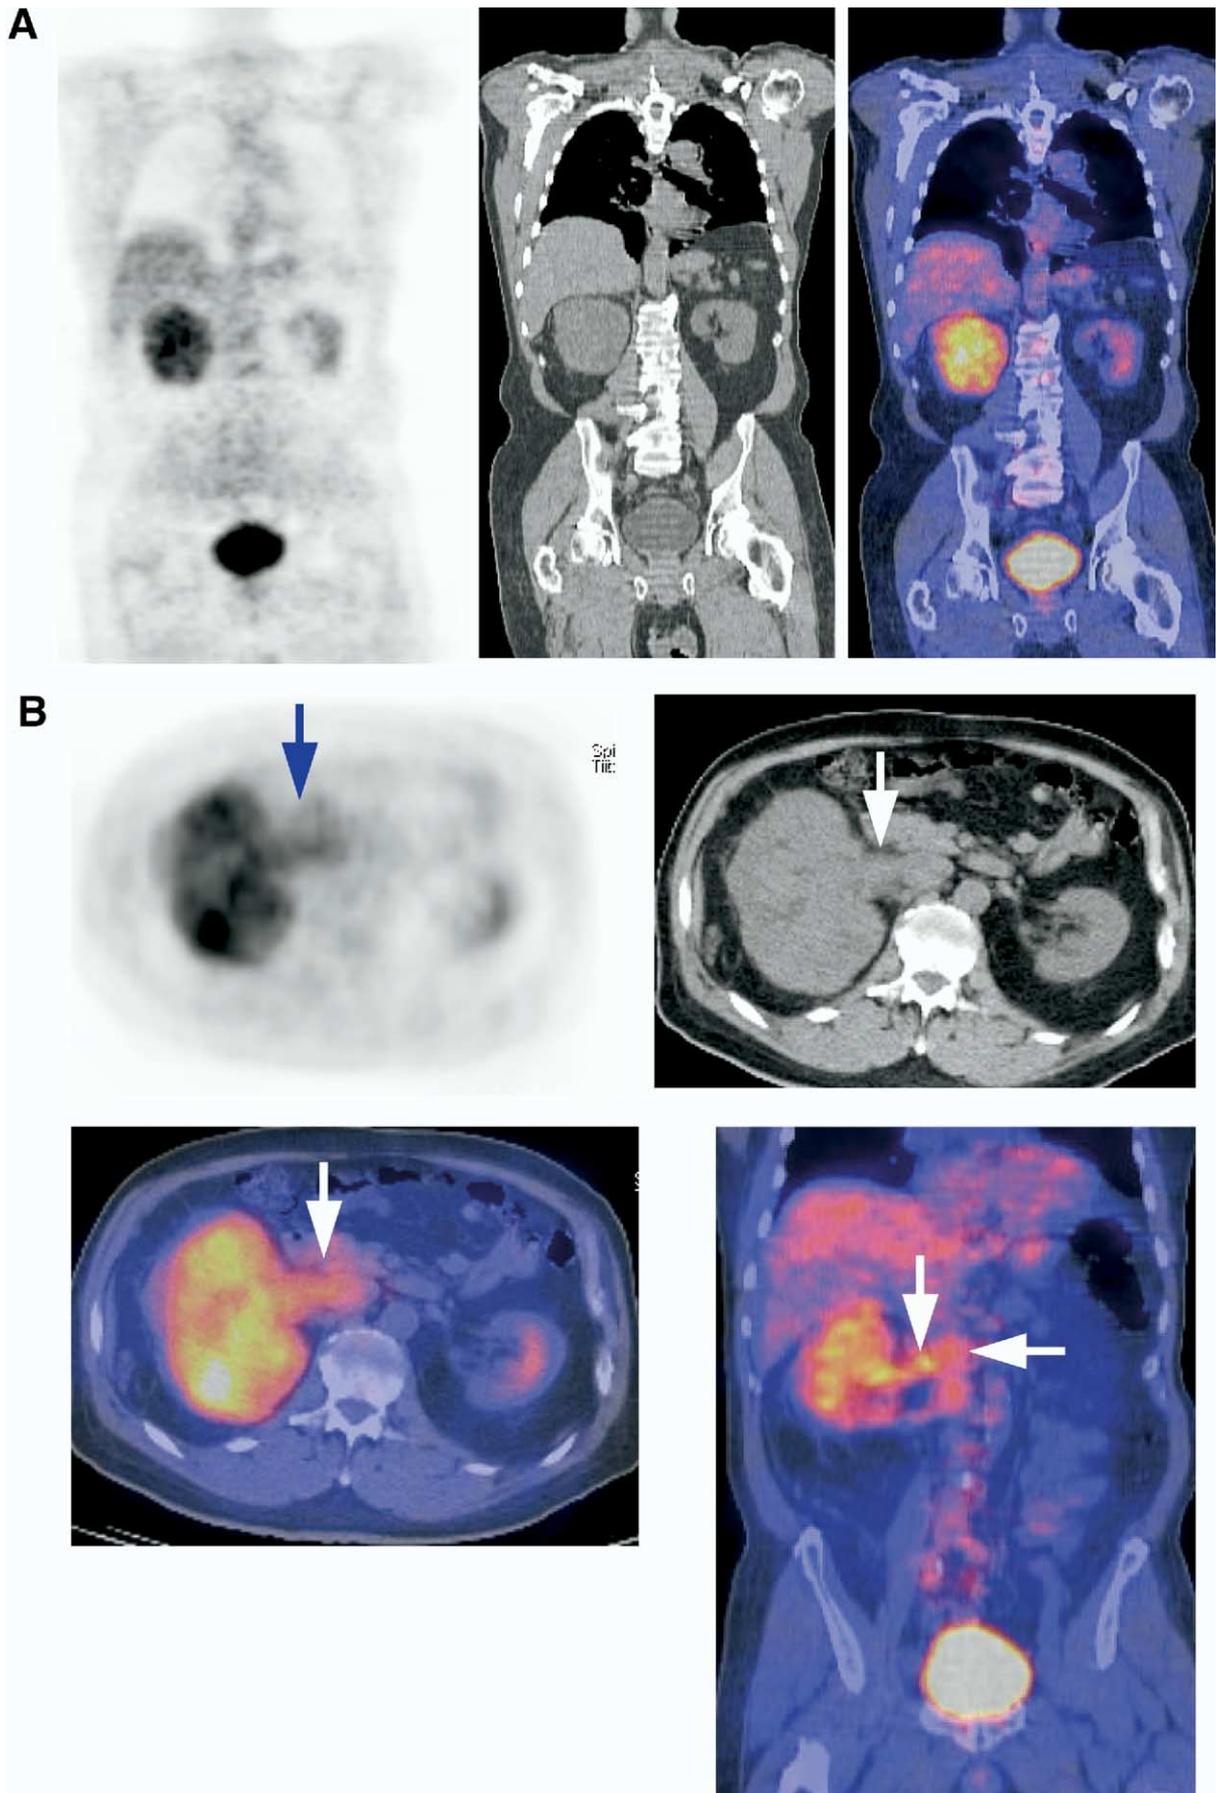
Staging of RCC. (A) Coronal FDG-PET images, coronal CT, and coronal PET/CT fusion images show abnormal FDG uptake in a right renal mass. (B) Transaxial PET, CT, and fusion images, as well as coronal PET-CT fusion image, show tumor extension into the right renal vein and inferior vena cava. (Color version of figure is available online.)
